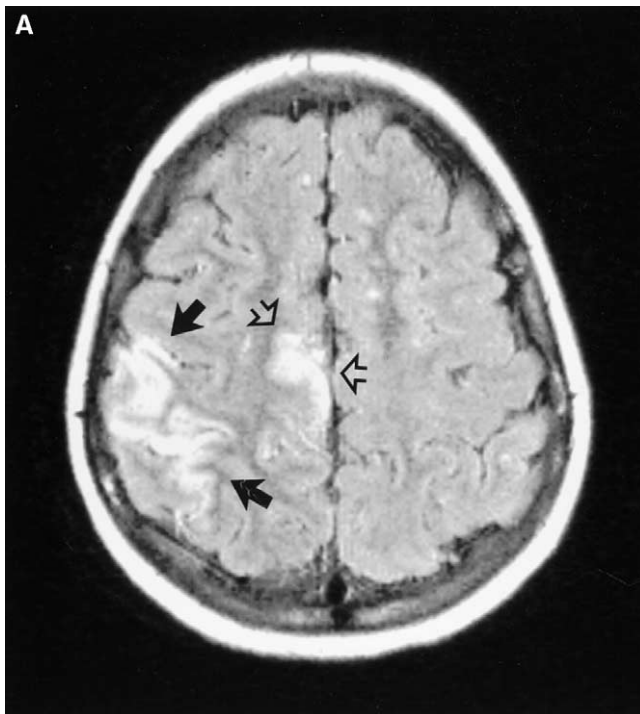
(A) A 10-year-old girl with history of chronic headaches and developmental delay presented with sudden onset left-sided weakness. FLAIR MRI scan demonstrates right middle cerebral artery (*large arrows*) and right anterior cerebral artery (*open arrows*) distribution ischemic infarcts. (B) Axial contrast enhanced T1-weighted MR scan shows enlarged collateral vessels (*arrowheads*).
